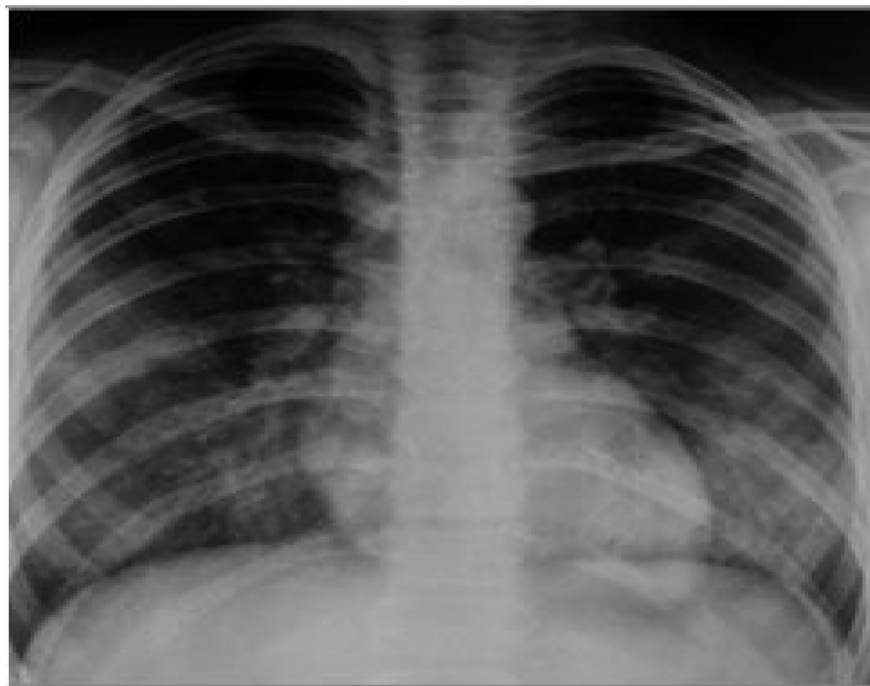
Chest X-ray in AP view after mechanical ventilation weaning demonstrated a significant improvement in diffuse opacities of both lungs.
